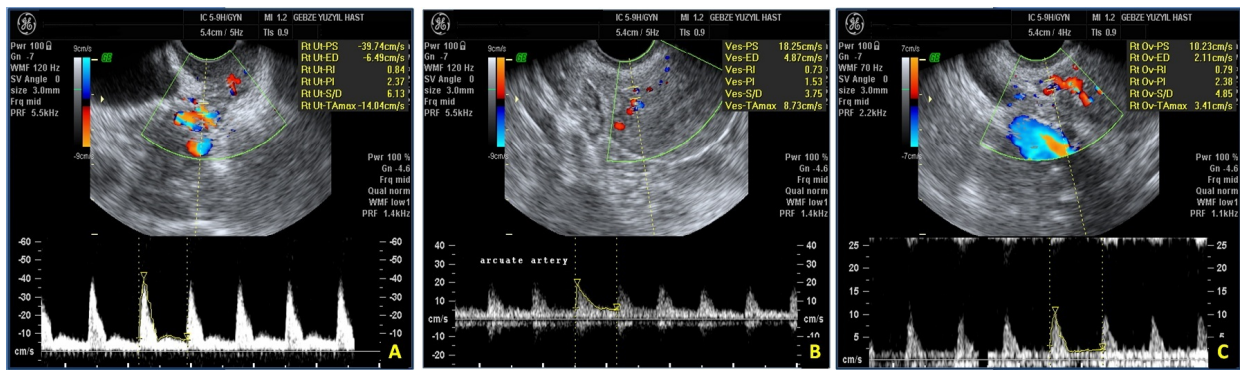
Measurement of the Doppler indices. (A) Uterine artery. (B) Arcuate artery. (C) Utero-ovarian artery.
